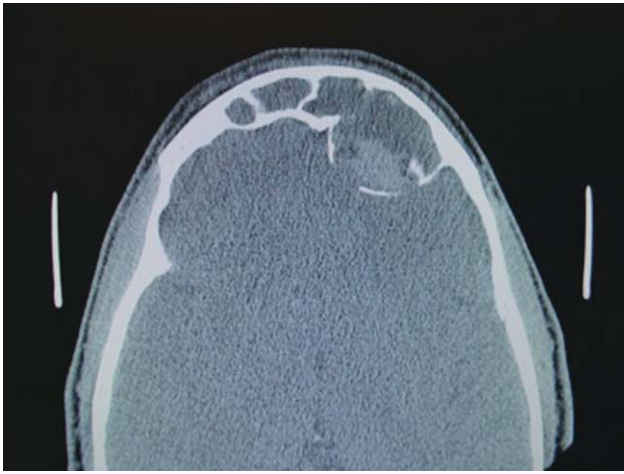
Axial computed tomography of the frontal sinus demonstrating an expansile heterogenous mass in the right frontal sinus extending into the right frontal lobe. The inflammatory process has extended from the right frontal sinus to involve the left frontal sinus.
